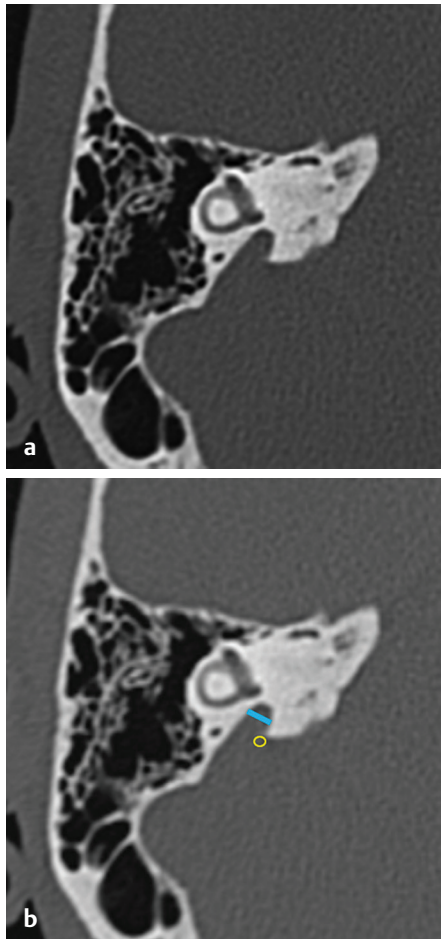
(a, b) HRCT temporal bone, axial section, bone window showing measurement of the width of vestibular aqueduct at the midpoint (blue line) and at operculum (yellow O).
